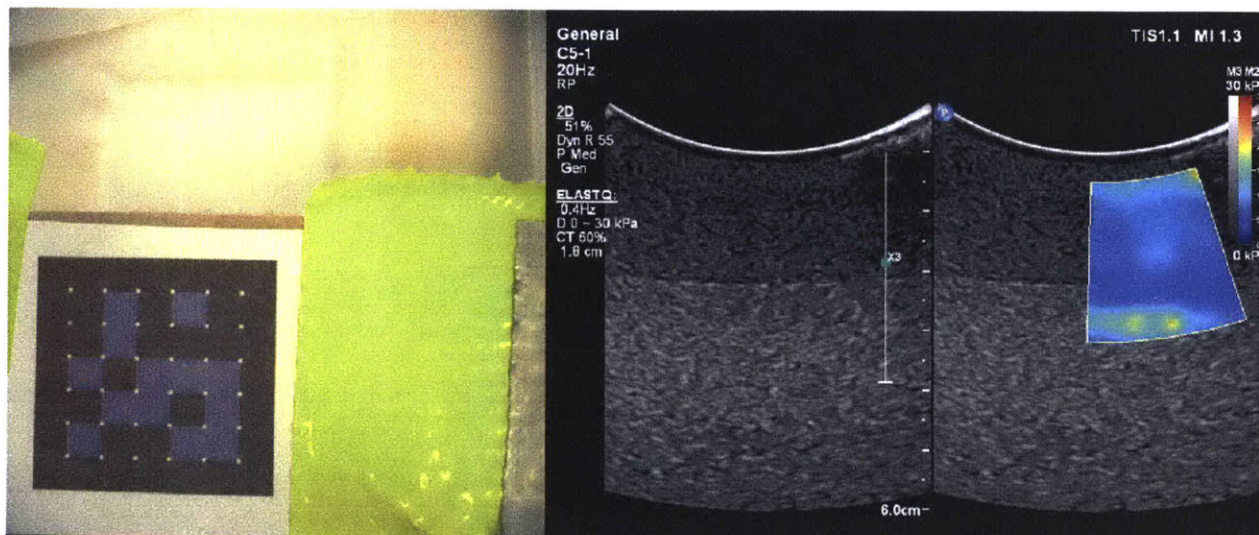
Camera and ultrasound image stream as collected with the volume elastography setup
